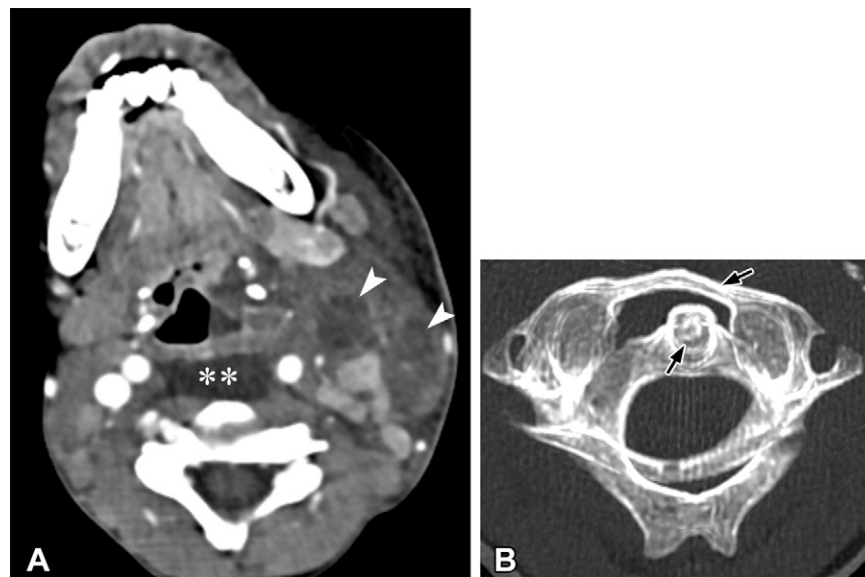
Grisel syndrome diagnosed in a 7-year-old boy with neck swelling and restricted movement. (A) Axial CECT image of the neck reveals suppurative lymphadenitis (arrowheads) and a large retropharyngeal effusion (*). (B) Axial maximum intensity projection bone CT image shows abnormal rotation and subluxation of C1 on C2 (arrows), which were repaired.
